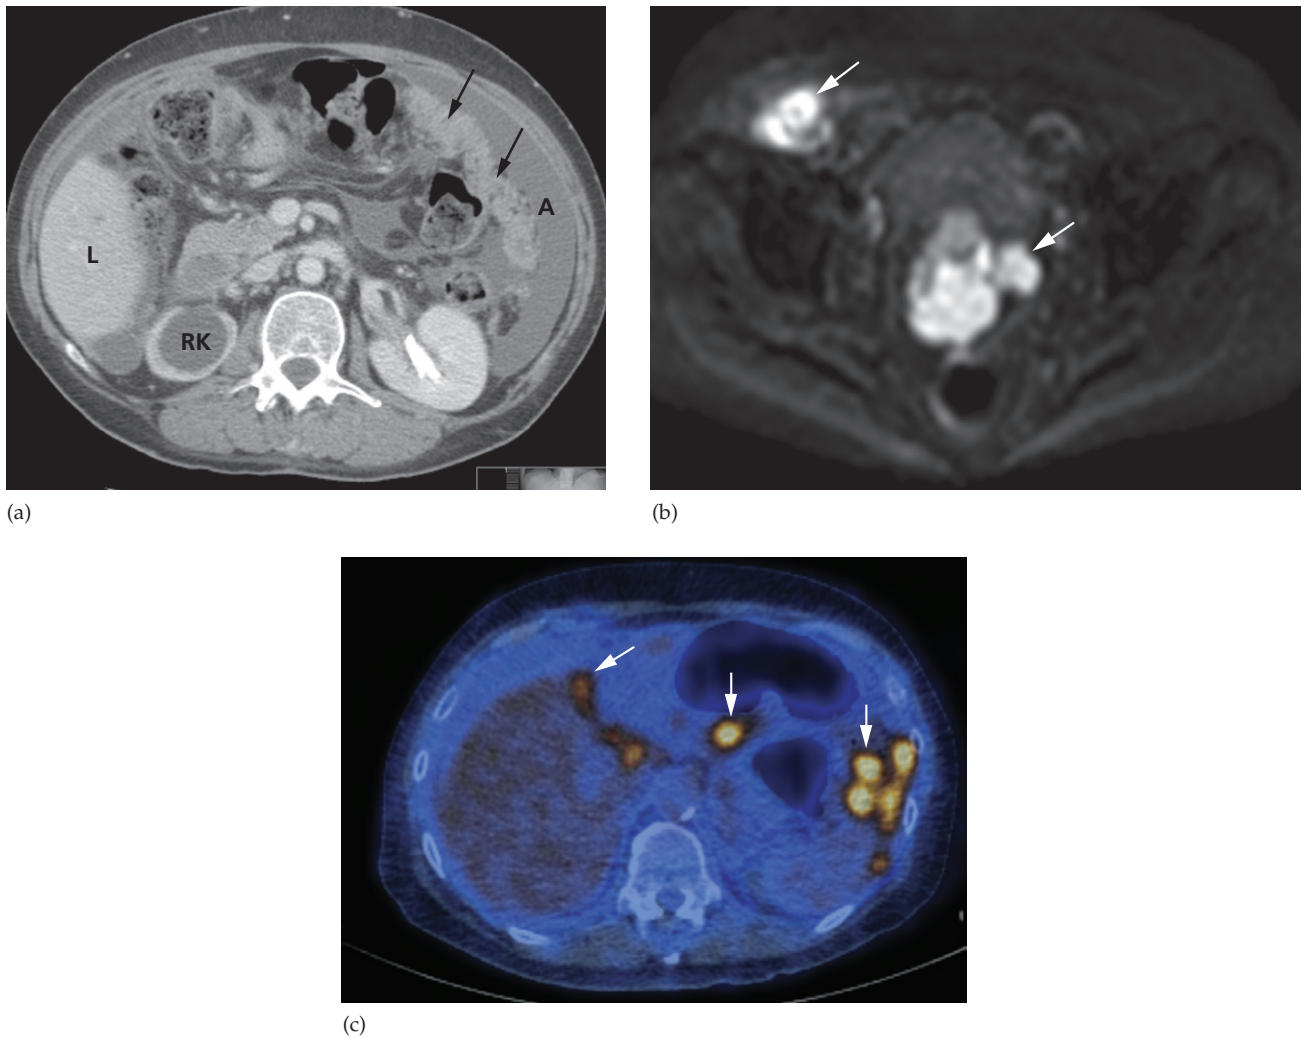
Intraoperative spread of ovarian carcinoma in three different patients. (a) CT demonstrating ascites (A) and an 'omental cake' of tumour deposits (arrows). There is hydronephrosis of the right kidney (RK). L, liver. (b) Diffusion-weighted MRI, b 1000 image, demonstrating the high signal intensity of peritoneal deposits (arrows). (c) Fused FDG-PET/CT demonstrating multiple FDG-avid peritoneal deposits (arrows) in the upper abdomen.
